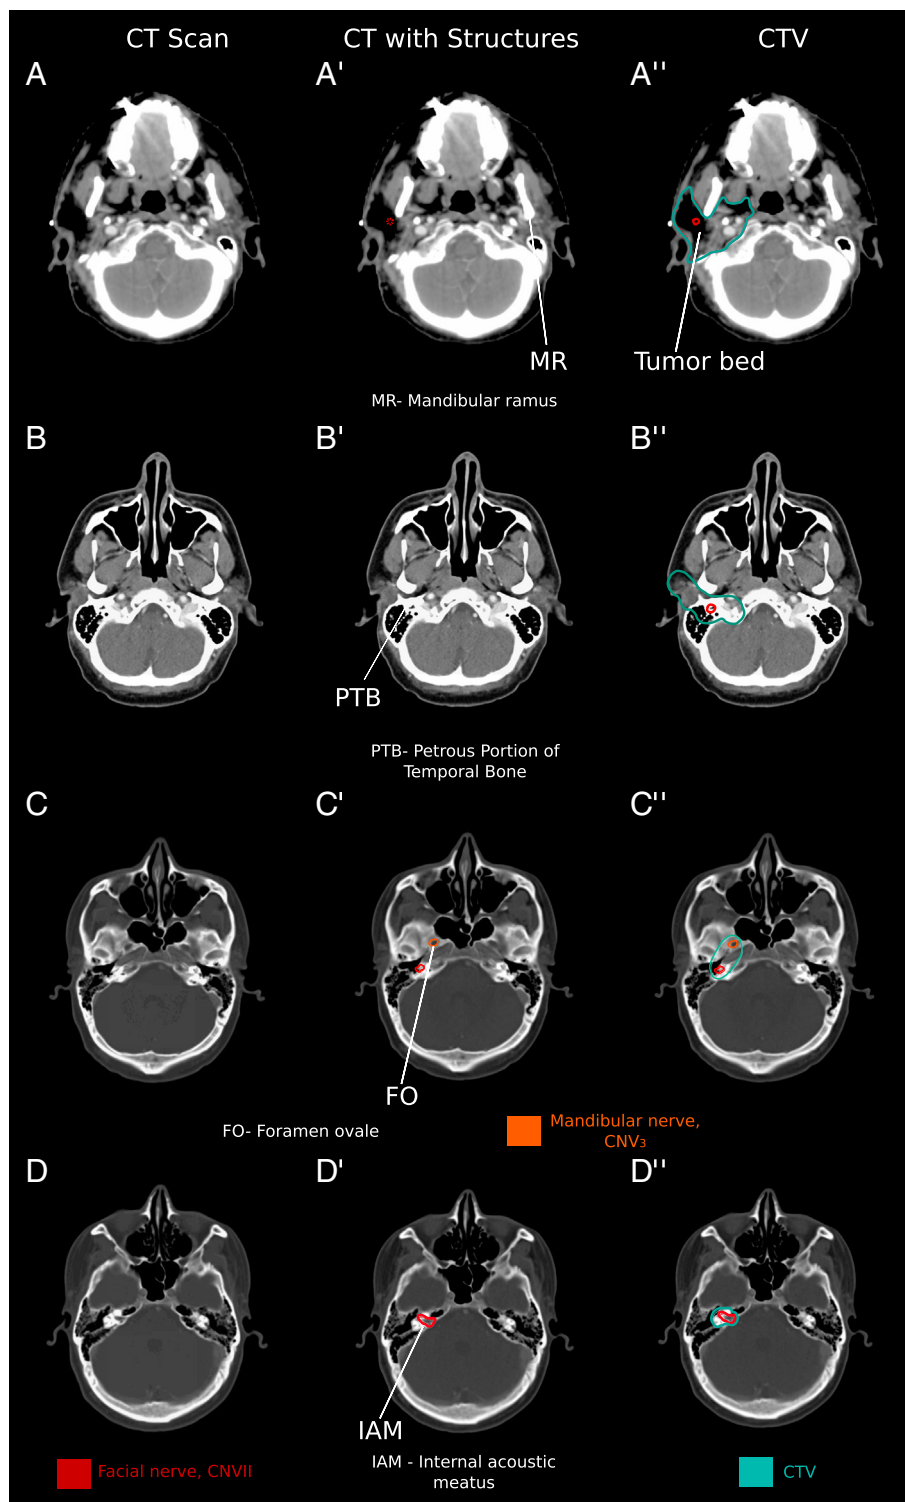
Axial computed tomographic (CT) slices of the parotid gland and related cranial nerves. The left column (A-D) depicts axial CT images of the area of interest, the middle column (A'-D') depicts the nerves contoured on CT images, and the right (A''-D'') depicts these contours with a clinical target volumes (CTV; shown in teal). The facial nerve (cranial nerve [CN] VII) (shown in red), pierces the parotid gland tissue. The mandibular nerve (CN V₃) (shown in orange) can also be involved in cancers of the parotid gland via internerve connections. The mandibular nerve and the facial nerve are at risk for harboring cancer in the setting of perineural invasion.
